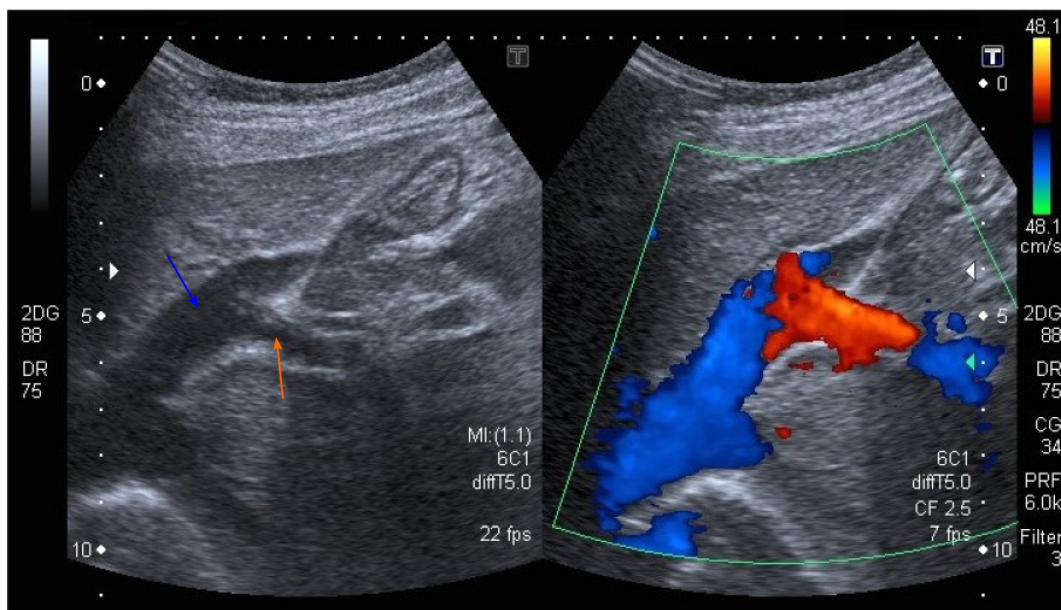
Abdominal ultrasound with Doppler color flow (case 1). An anomalous vascular connection between the left hepatic vein (blue arrow) and left portal vein (orange arrow) is seen.
